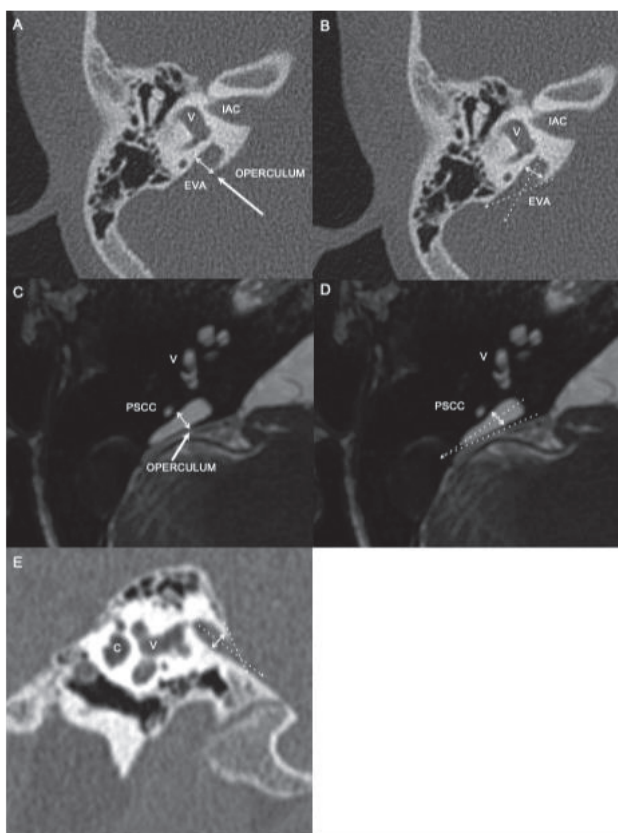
A, B: axial CT image of the right temporal bone: Operculum measurement is shown by arrow in A, midpoint measurement by arrow in B. C, D: axial MR T2 image of the right inner ear revealing an enlarged endolymphatic duct and sac: Operculum measurement is shown by arrow in C; Midpoint measurement is shown by arrow in D. E sagittal CT image of the right temporal bone. Midpoint measurement is shown by arrow. C = cochlea, V= vestibulum, IAC = internal auditory canal, EVA= enlarged vestibular aqueduct. PSCC= posterior semicircular canal.
